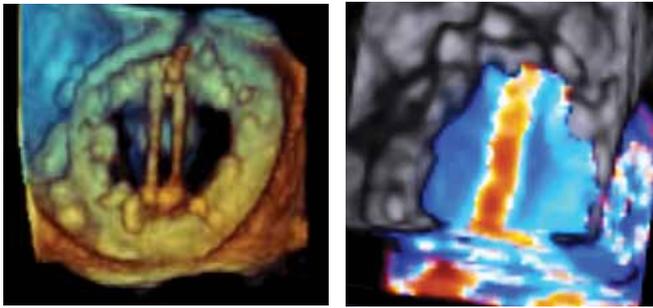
Examples of 3-dimensional echocardiography and Doppler images of a bileaflet mechanical valve in the mitral position from the left atrial view, showing the whole valve apparatus and flow through the valve, with higher velocity between the leaflets.
